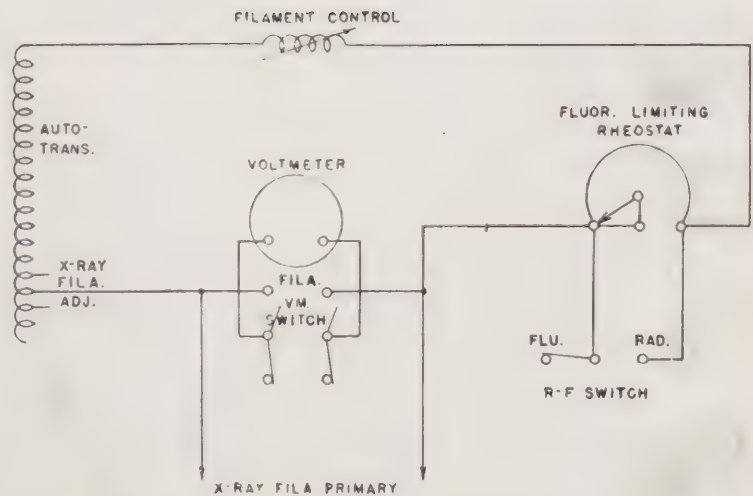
X-ray tube filament circuit—Item No. 96085.
